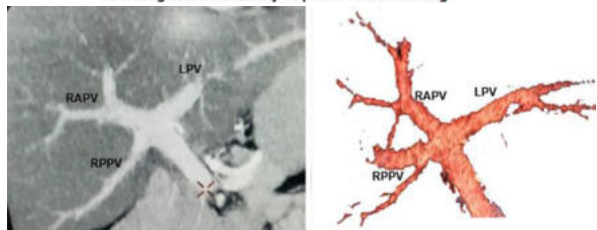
CT axial reformatted and VR image in the portal venous phase showing trifurcated (Type II) portal vein
